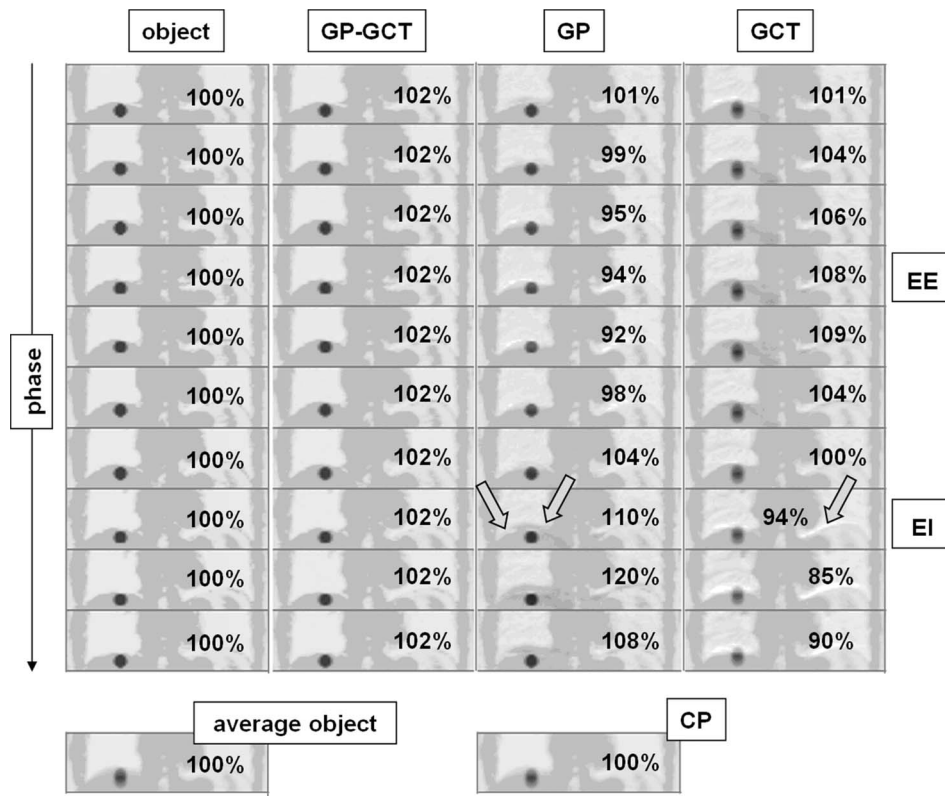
Coronal sections through PET series associated with the 20 mm dome of the liver tumor in patient 4. The figure presents the PET object at each gate, the average object, three gated reconstructed image sequences, and a nongated reconstruction, as explained in the text. SUV recovery is indicated with a percent value in each frame of the picture. Arrows indicate prominent artifacts. Abbreviations refer to gated PET, gated CT, conventional PET, end expiration, and end inspiration.
